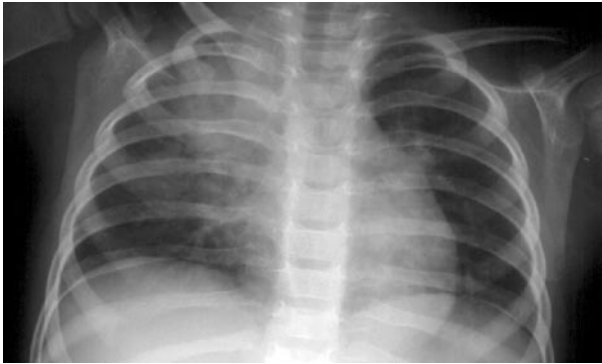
Chest radiograph demonstrating multilobar pneumonia.
